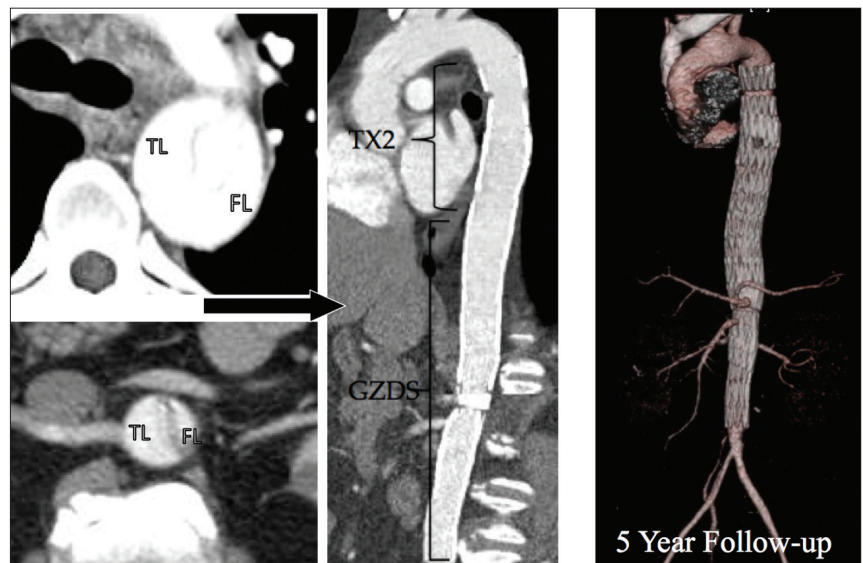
Distal aortic dissection treated with a proximal TX2 graft; more distal intimal disruption and bare stenting (Gianturco Zenith Dissection Stent, Cook Medical) create the uniluminal aorta. Initial and 5-year follow-up CT shows complete elimination of the false lumen.
